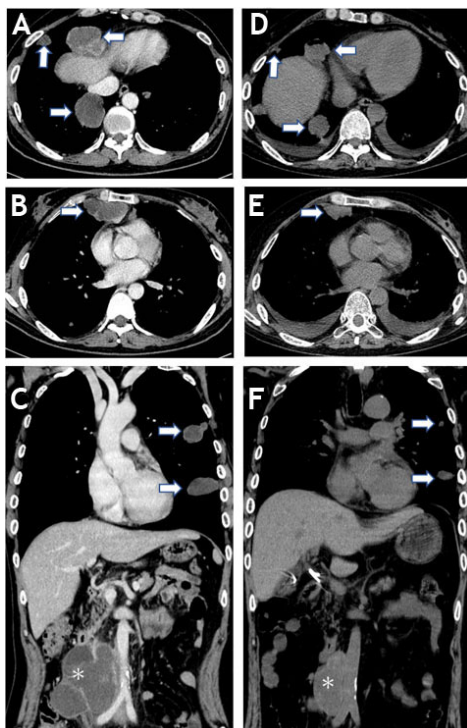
Computed tomography findings before (A–C) and after whole chemotherapy (D–F). (A, B, D, E) Lung metastases (arrows), (C, F) retroperitoneal lymphadenopathies (asterisks). Each metastatic tumor showed severe necrosis with heterogenous opacity suggesting hemorrhagic necrosis (A–C). Despite the partial response to chemotherapy, significant multiple tumors remained.
